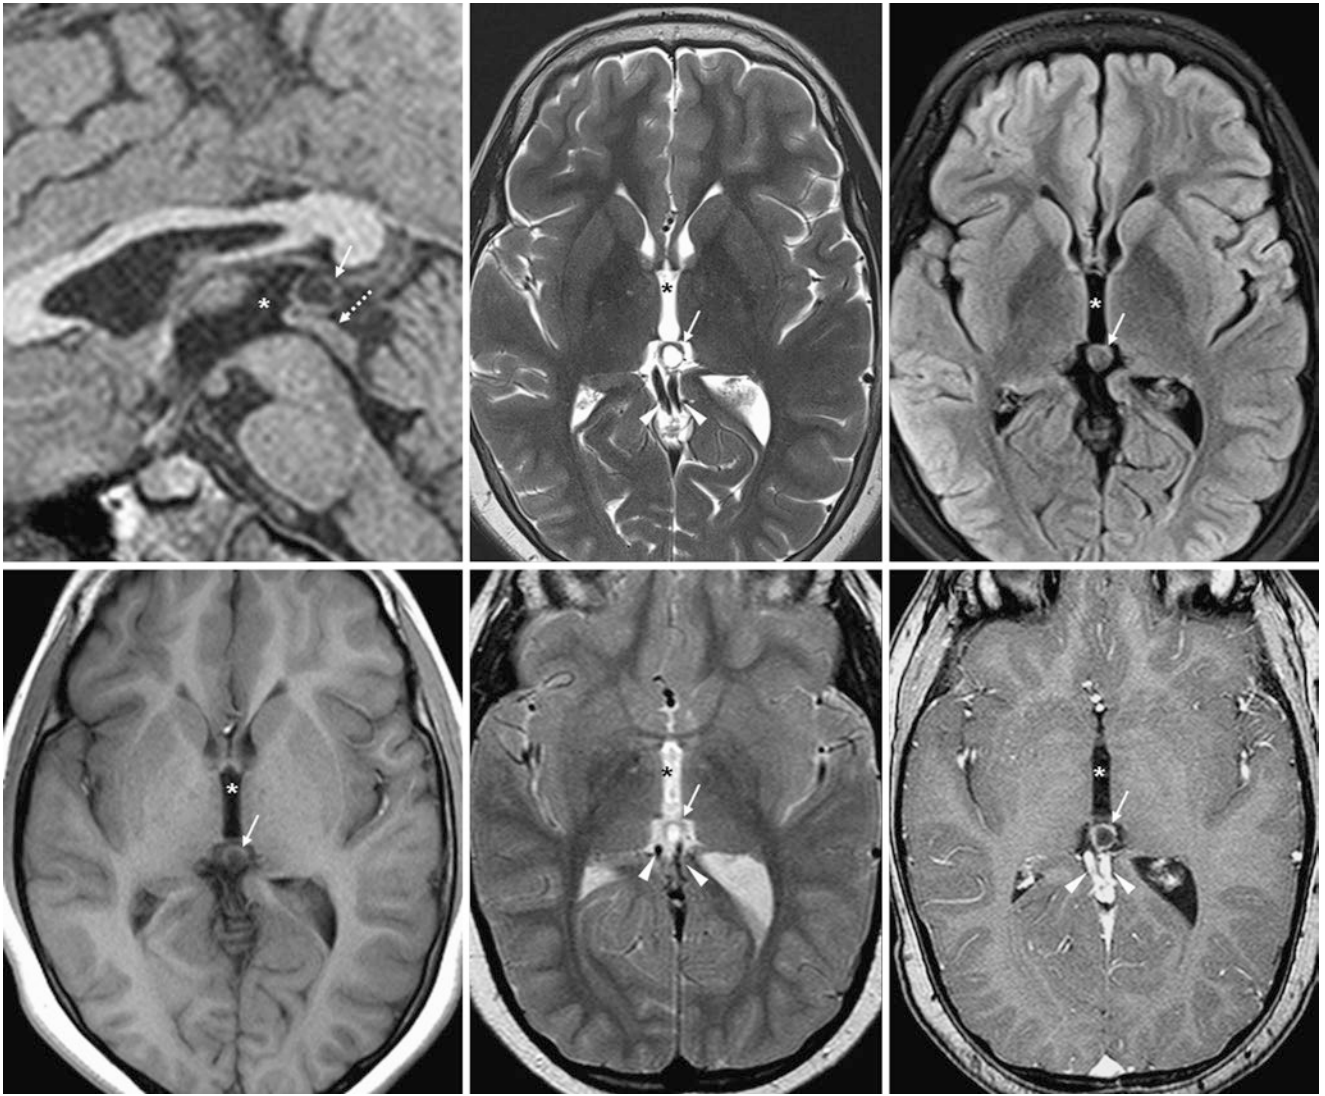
An asymptomatic 12-year-old who was evaluated for developmental delay underwent a 3 T MRI. A 9-mm pineal cyst (*thin arrows*) is depicted on sagittal 1-mm thickness T1WI (*top left*), axial T2WI (*top middle*), FLAIR (*top right*), and axial T1WI (*bottom left*). This was unchanged from 5 years earlier (1.5 T) on T2WI (*bottom mid-*
